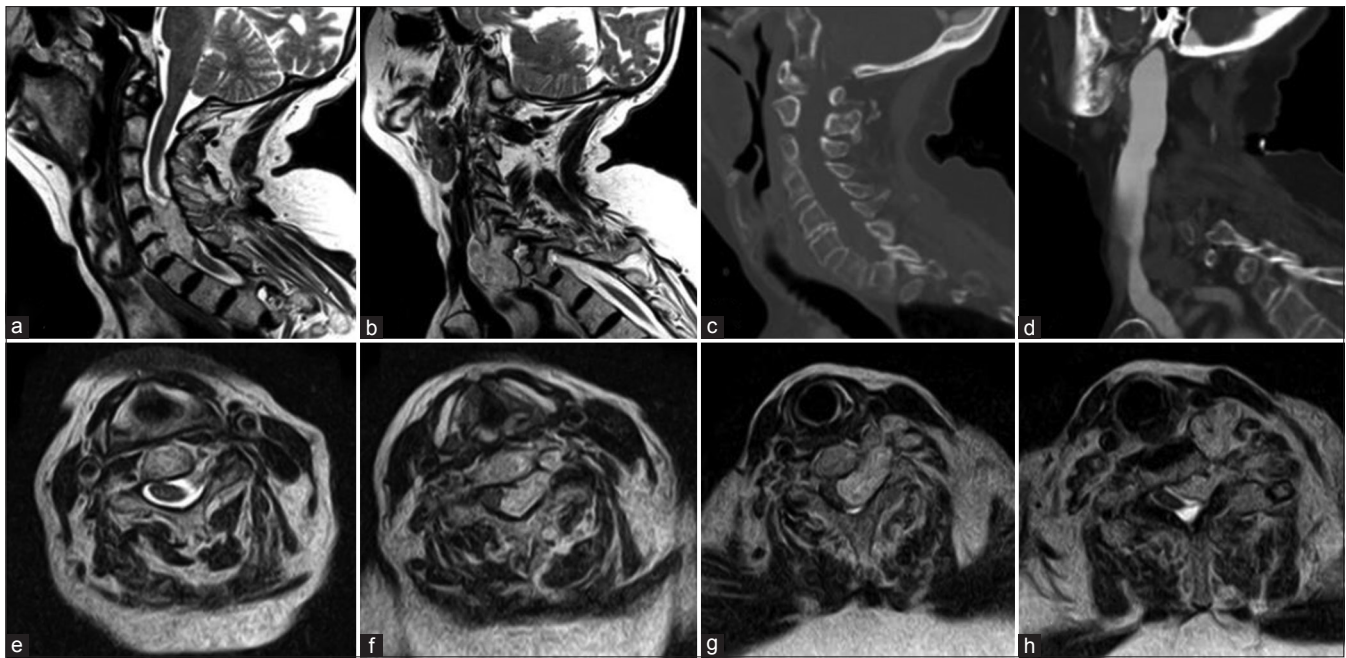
(a) T2WI showing the intraspinal portion of the mass. (b) T2WI showing extraspinal portion of the mass. (c) CT showing intact vertebral bodies without bone involvement. (d) CTA showing dilation of the internal jugular vein. (e-h) T2WI axial cuts at C4, C5, C6, and C7, respectively. Abbreviations: CT, computed tomography; CTA, computed tomography angiography; T2WI, T2-weighted image
